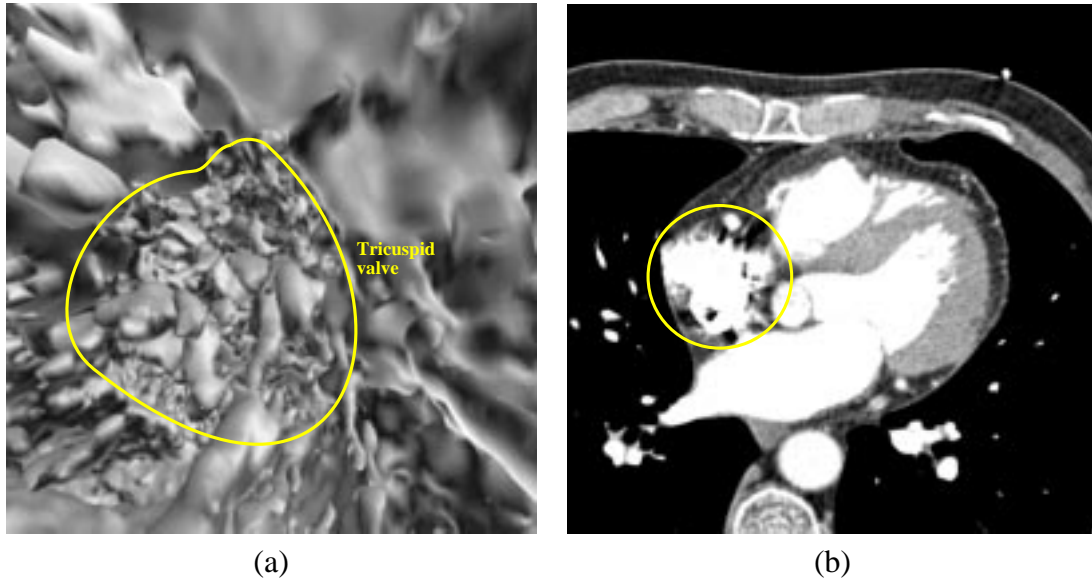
Artifacts in the right atrium due to beam hardening; (a) from an endoscopic view (yellow line marks the approximate position of the tricuspid valve) and (b) in a CT image slice (yellow line marks the right atrium).
